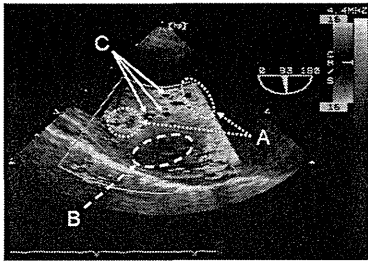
Example of color Doppler imaging of a thoracic aneurysm in systole with indications of measurement errors. (A) Aliasing, (B) wall filter, and (C) lack of data.
